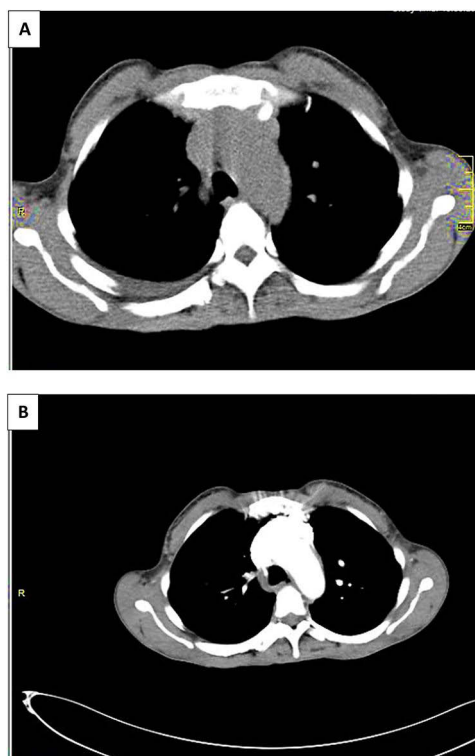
(A and B) Axial CT images of the chest demonstrating clear lung fields with no evidence of pulmonary metastases.
